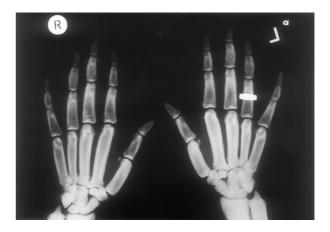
Antero-posterior radiograph of the hands of an affected adult. The shafts of the tubular bones are widened and irregular, with marked cortical hyperostosis.
